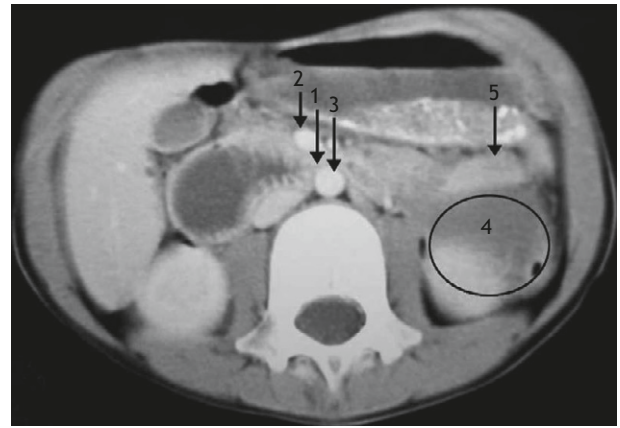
Abdominal computed tomography revealed dilatation of stomach and duodenum with obstruction site (arrow 1) between superior mesenteric artery (arrow 2) anteriorly, and abdominal aorta (arrow 3) posteriorly. Presence of a cystic mass about 3–4 cm is also seen in the left upper quadrant (circle 4) with jejunal lumen compressed anteriorly (arrow 5).
